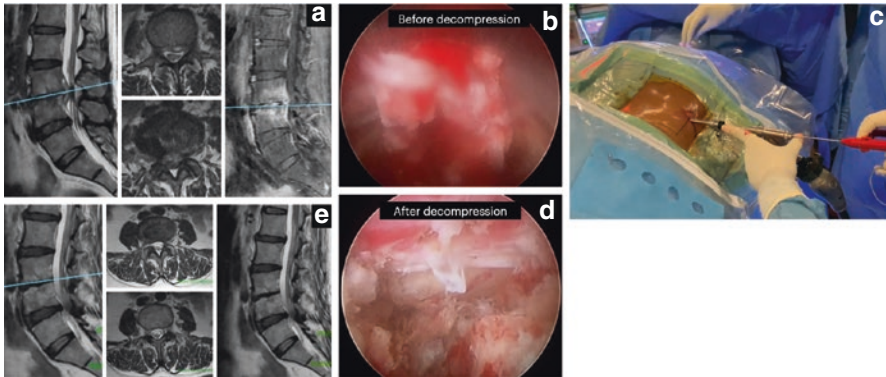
(a) Preoperative MRI pictures showing L34 disc space infection with localized ventral epidural abscess. (b) Endoscopic picture immediately after insertion of endoscope. (c) Clinical picture of showing handling of transforaminal endoscope. (d) Endoscopic picture after completion of debridement and decompression. (e) Postoperative MRI pictures showing complete resolution of infection
